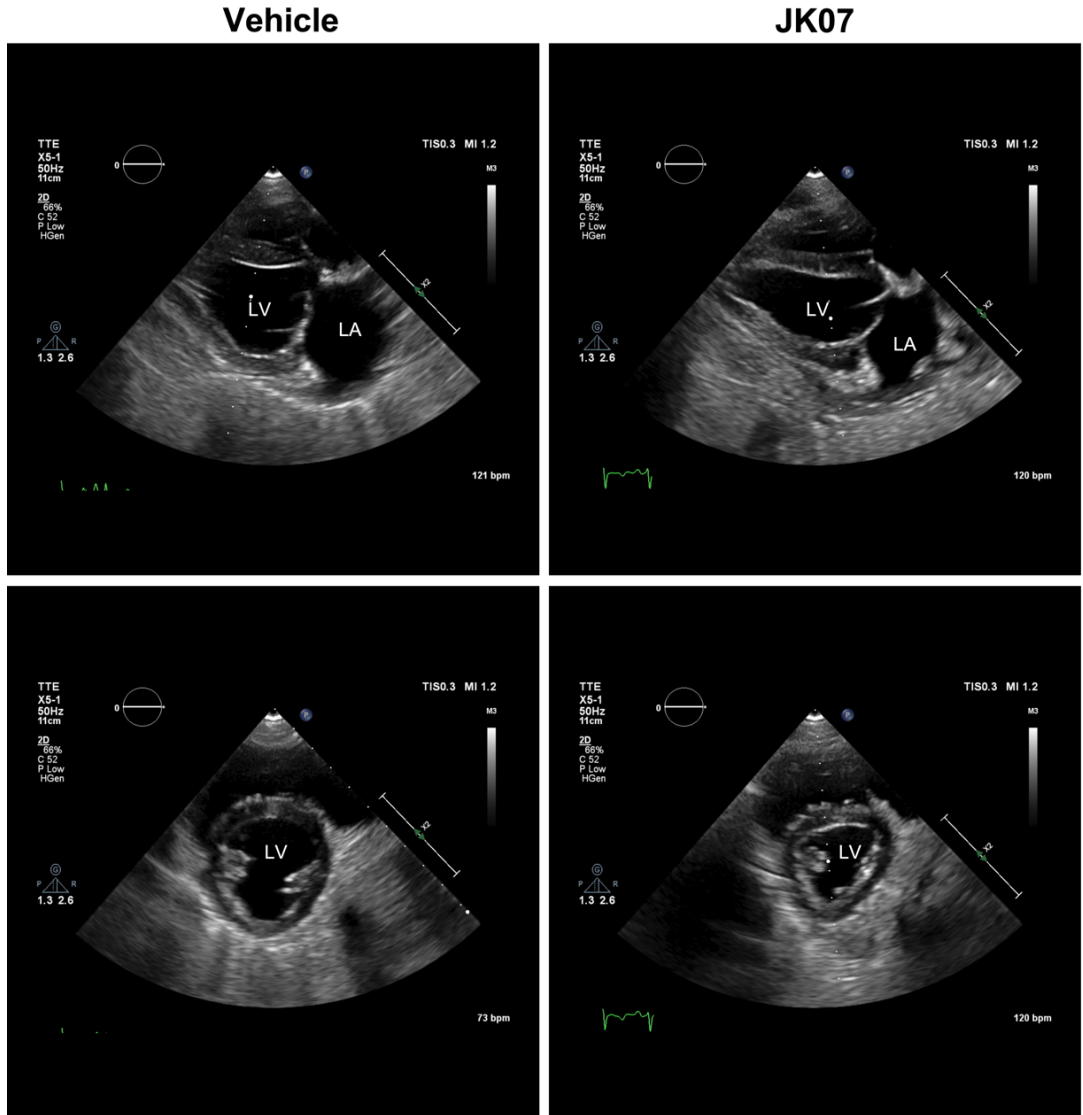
Representative echocardiographic images. Upper: images taken in a view similar to parasternal long axis. Lower: images taken in a view similar to parasternal short axis. All images displayed were taken on day 31 of the experiment and pictures were taken in diastole. LA = left atrium, LV = left ventricle.
